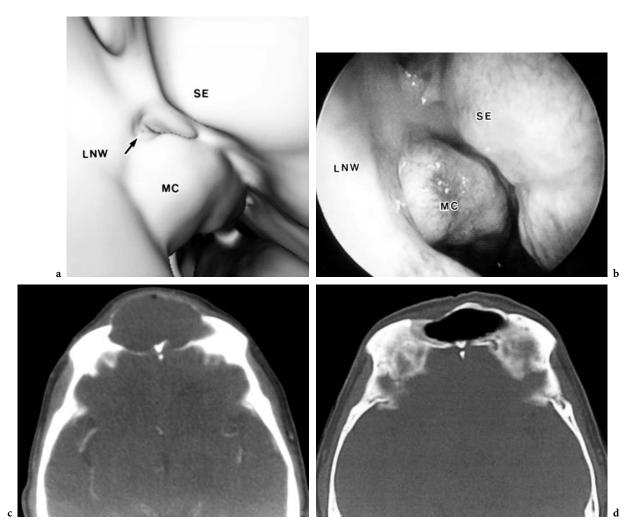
Frontal mucocele in a 52-year-old man. Virtual endoscopic (a) and surgical endoscopic (b) images of anterior portion of the right nasal cavity are shown. Also presented are preoperative (c) and postoperative (d) CT findings. The crosscursor (*arrow*) indicates a suggested puncture site for endoscopic sinus surgery. The wall of the frontal mucocele is shown behind the nasal bone. The mucocele was successfully removed by the endonasal surgery. *SE*, nasal septum; *MC*, mucocele; *LNW*, lateral nasal wall. From: Nakasato: J Comput Assist Tomogr 2000; 24(3):486–492
